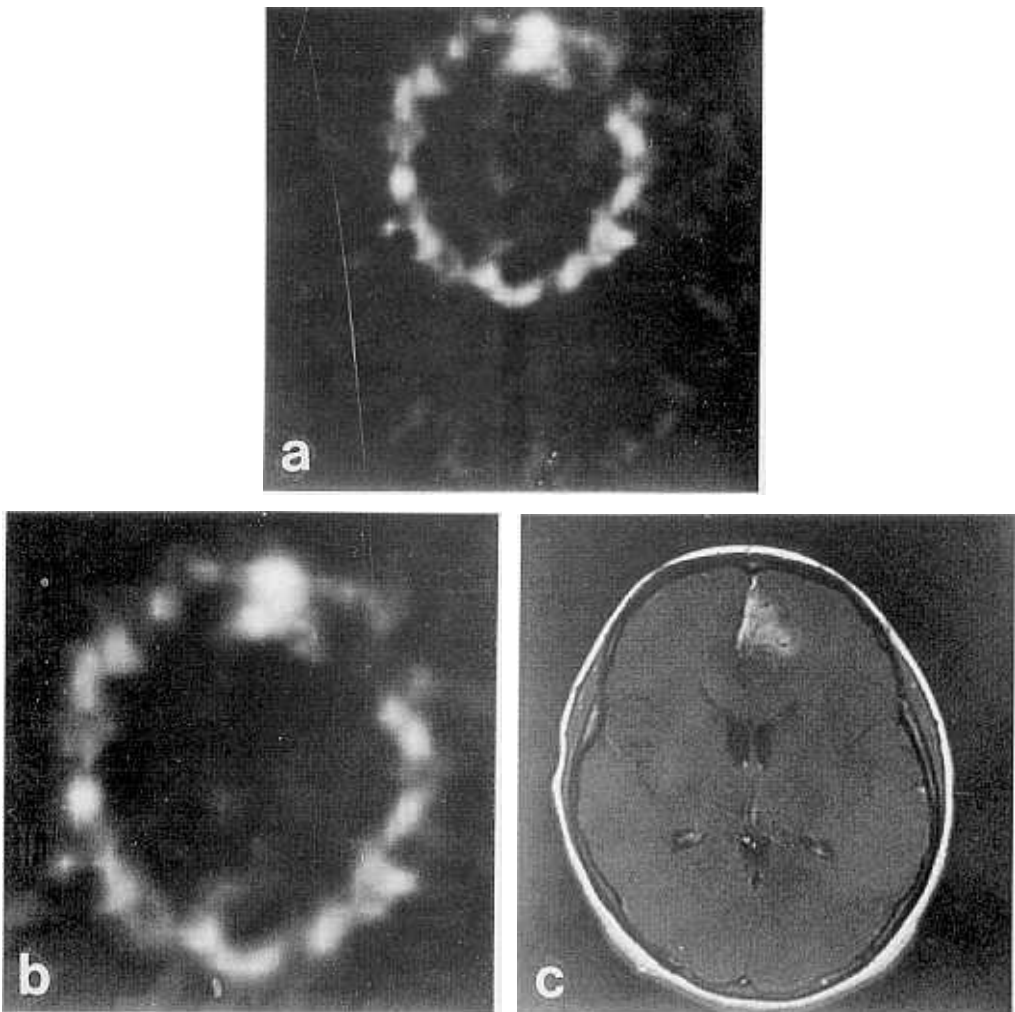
Above figures are (a) a SPECT image, (b) scaled and rotated image of (a) to fit MR image (c), and (c) MR image of corresponding slice of SPECT image (a).
